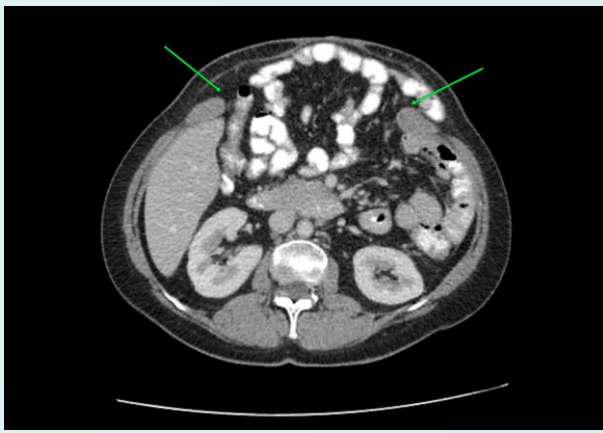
Arrows depicting the anterior abdominal wall defect as seen on CT scan.
